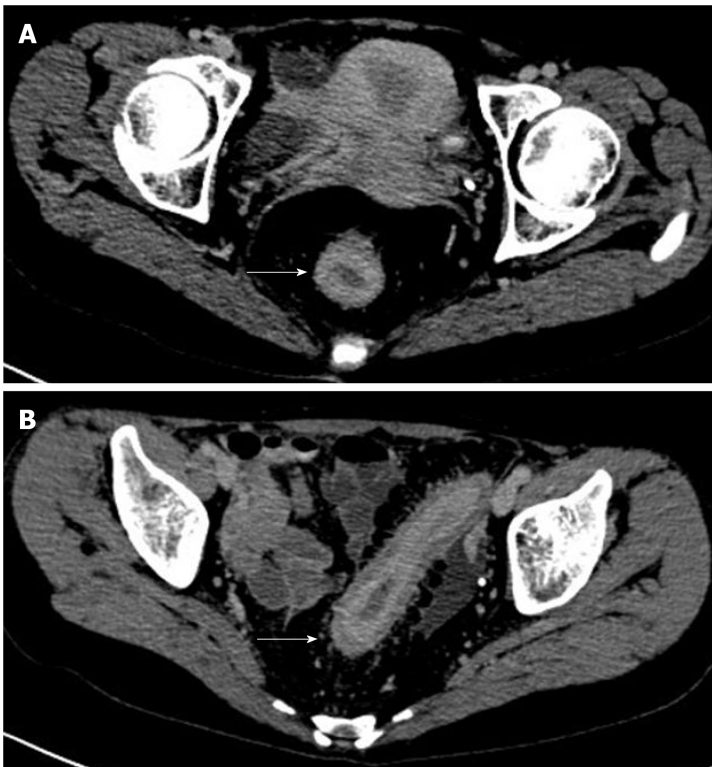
Preoperative computed tomography examination. A: The rectal wall thickened uniformly in stages, and the intestinal cavity was obviously narrowed; B: The rectal mucosal layer was obviously strengthened (the area indicated by the white arrow, 2019/11/28).
